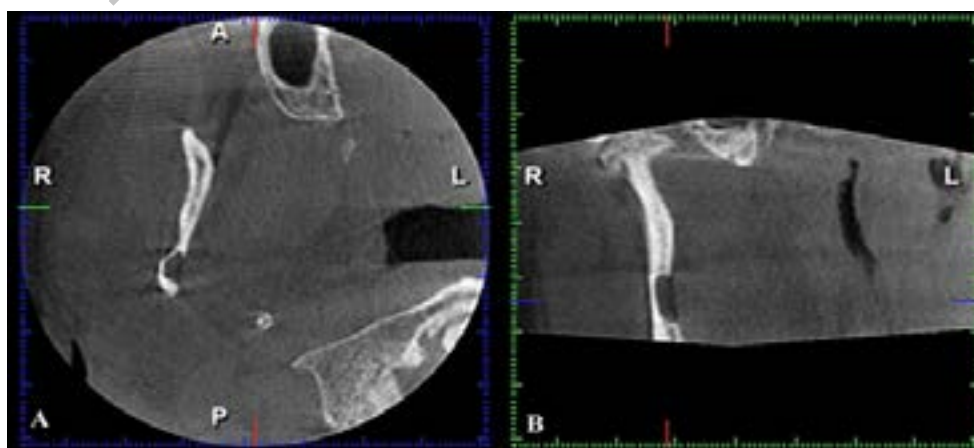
Cone-Beam Computed Tomography axial (A) and coronal (B) views show a well-defined bone defect on the lingual side of right mandible ramus.
